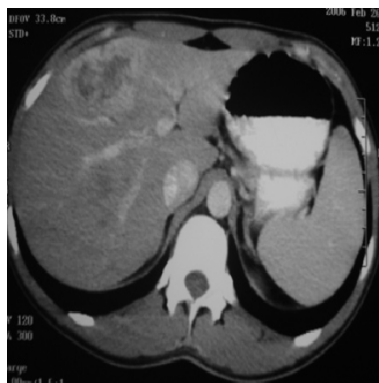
Abdominal CT scan performed five years ago which showed peripheral enhancement in the arterial phase.
